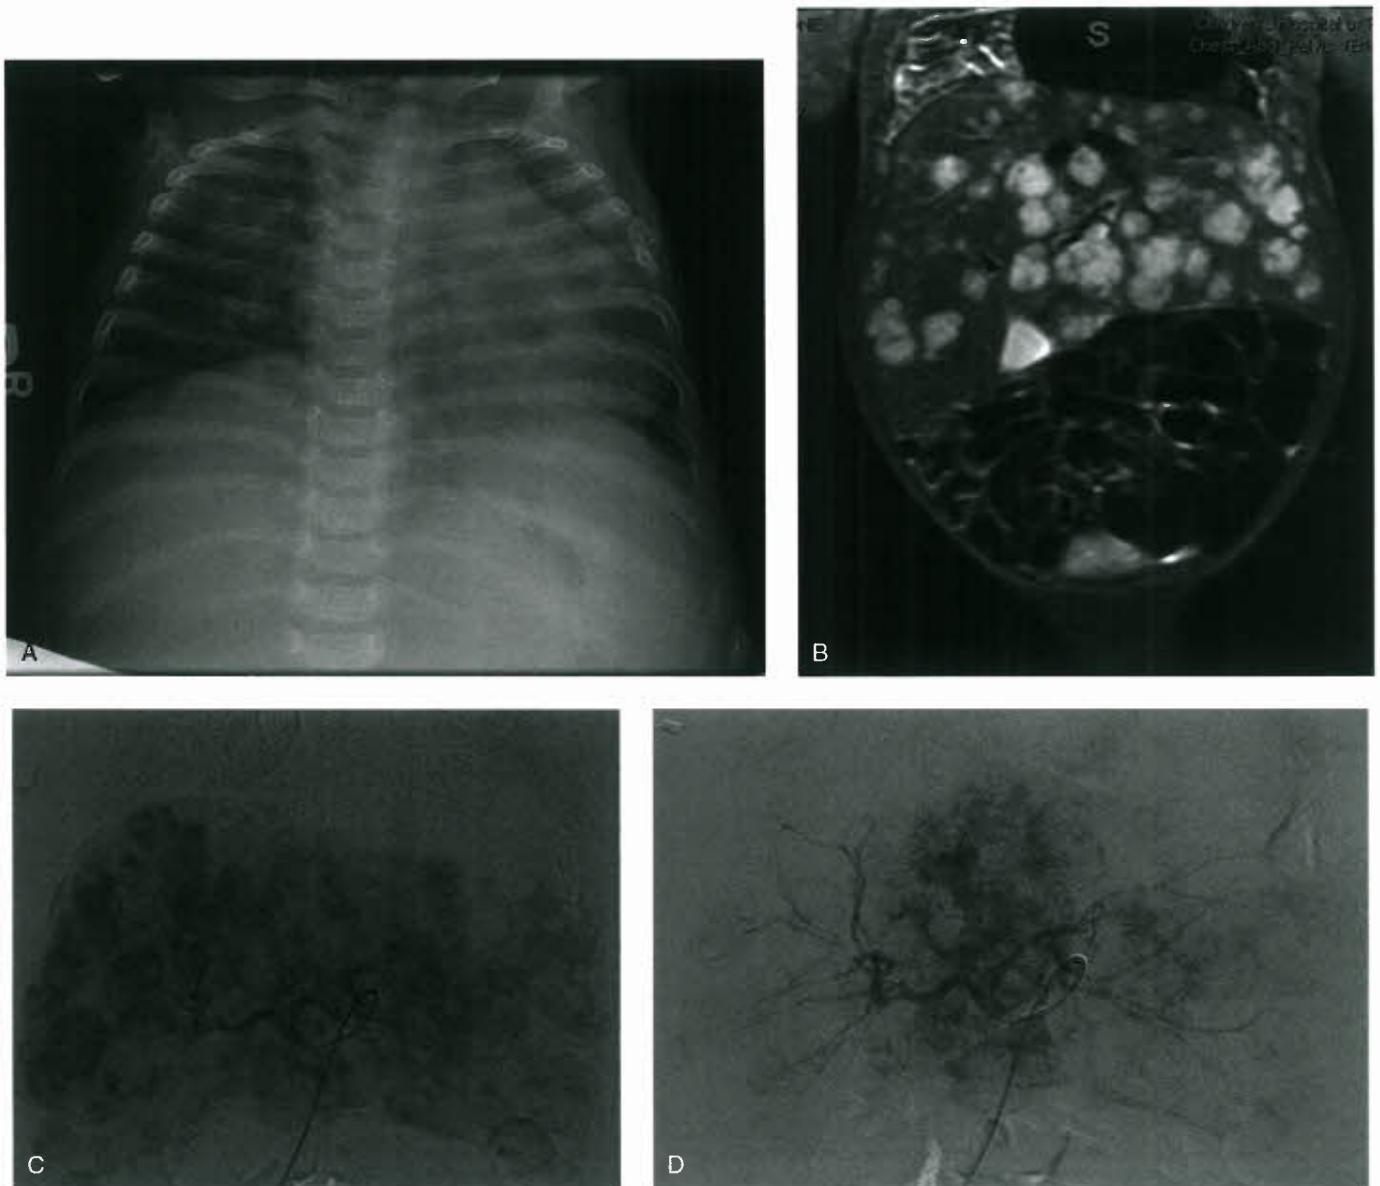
Hepatic hemangiomas. A: Chest radiograph of 5-month old with multiple hepatic hemangiomas and high cardiac output state. There is marked cardiomegaly with increased pulmonary vascular markings and hepatomegaly. B: Coronal section of T2-weighted abdominal MRI showing multiple homogenous, circular hemangiomas throughout the liver. C: Selective angiography of the hepatic artery prior to intervention, demonstrating multiple hemangiomas throughout both lobes of the liver. D: Selective angiography of the hepatic artery after particle embolization of liver hemangiomas in the right lobe. There is significant improvement with little contrast seen outside of the normal liver vasculature of the right lobe. The left lobe hemangiomas remain prominent. (Images courtesy of Anne Marie Cahill, M.D. Department of Interventional Radiology, The Children's Hospital of Philadelphia.)
